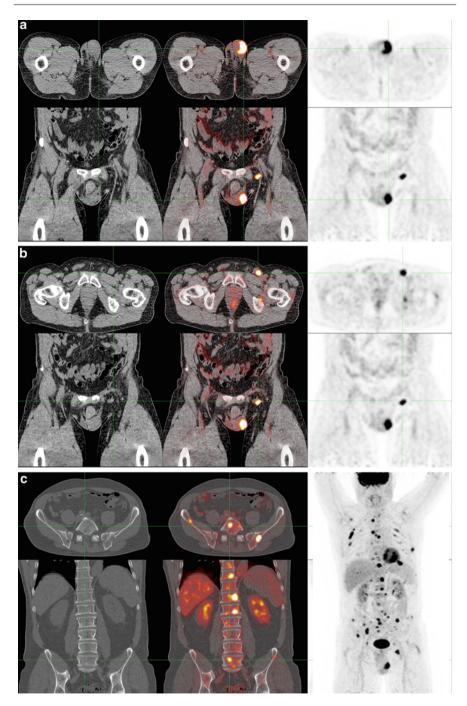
FDG-PET/CT scan of a patient with penile cancer. The penile tumor exhibits high uptake of FDG (\mathbf{a}). In the left groin, a prominent lymph node with high uptake of FDG is visualized (\mathbf{b}), which is highly suspicious for metastasis. In addition, multiple bone metastases can be seen in the rest of the body (\mathbf{c})
